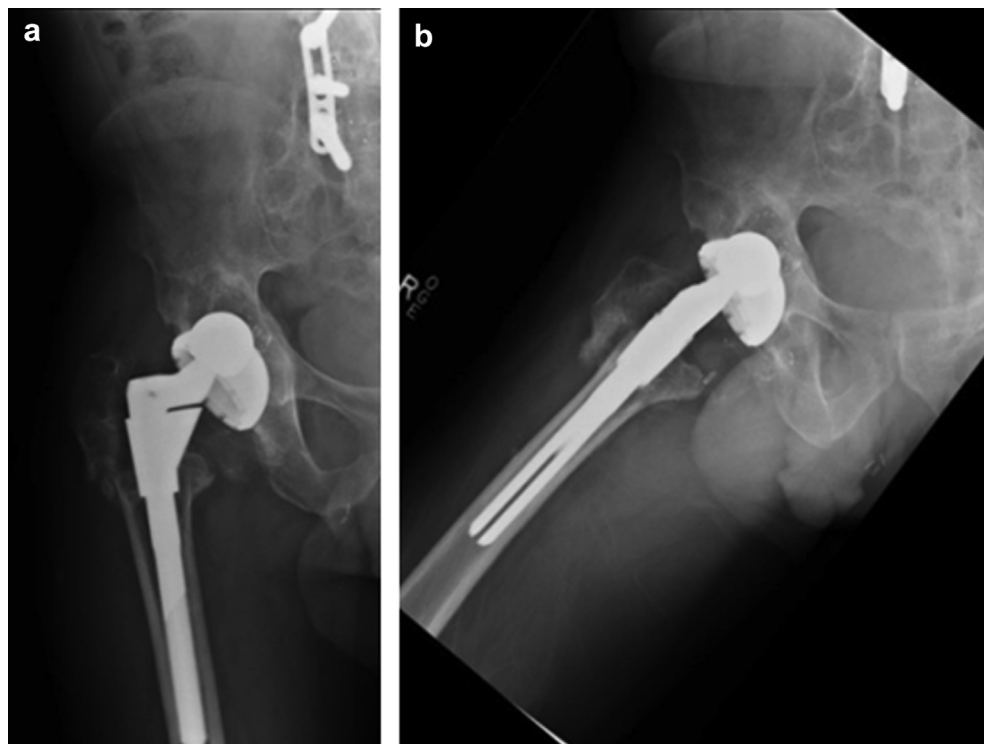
AP right hip (a) and lateral right hip (b) radiographs taken at the patient's initial clinic visit. The patient had fallen from standing height intervally. Radiographs demonstrate persistent right hip dislocation and stable lucency around the acetabular and femoral components, along with a new right greater trochanteric fracture that went onto nonunion.
